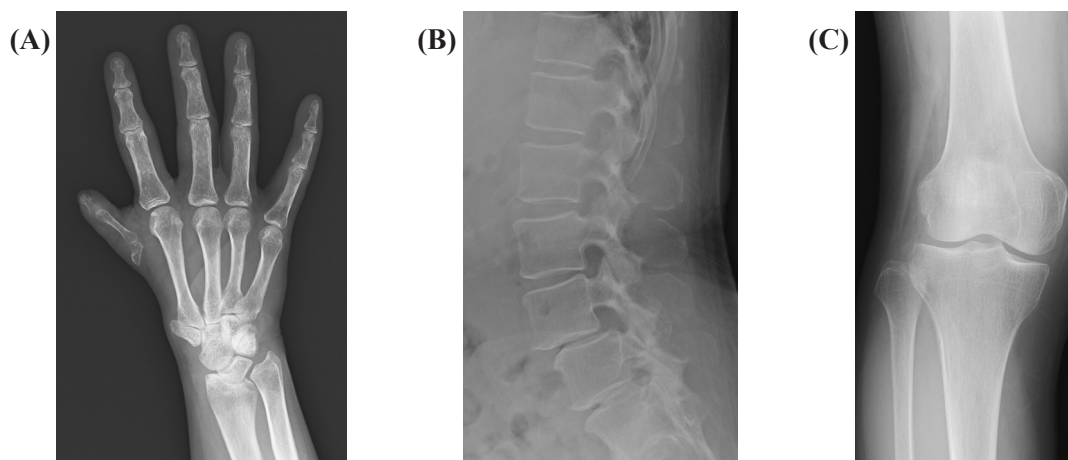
X-ray images of a female adult in her early 50s. In this female adult with thalidomide embryopathy, showing relatively mild upper-limb hypoplasia and no apparent lower-limb malformations, the right hand with thumb hypoplasia shows fusion of the carpal bones and a narrow, deformed radiocarpal joint (A). The lumbar spine shows narrow intervertebral spaces with endplate irregularity and spondylolisthesis (B). The right knee joint is inclined with the hypoplastic lateral femoral condyle (C).
